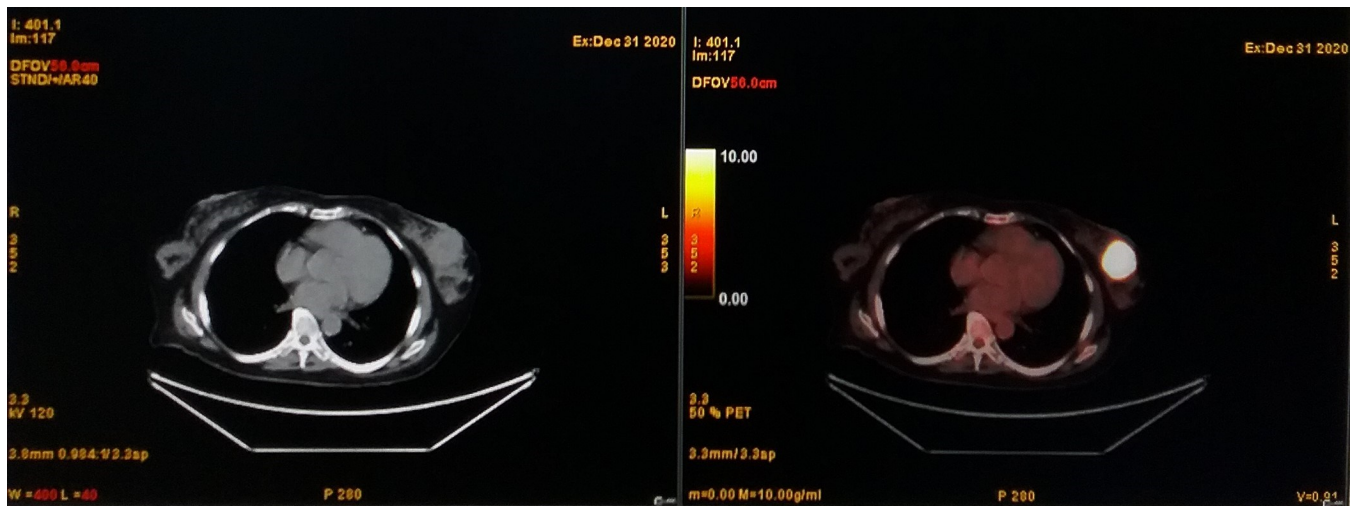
Axial PET/CT images demonstrate intensely FDG avid left breast lesion.
